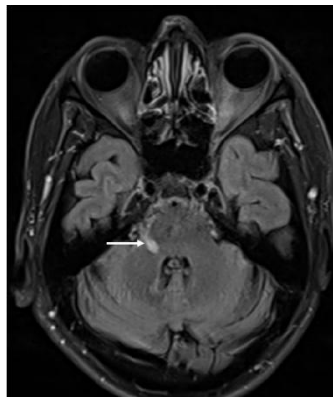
FLAIR post contrast axial section showing enhancement in root zone of right trigeminal nerve in pons (arrow).
